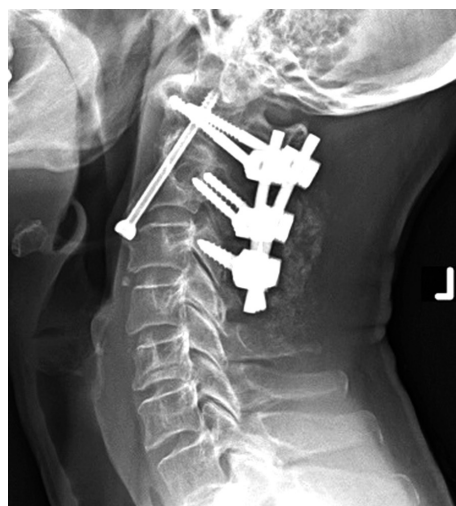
Three-month postoperative lateral radiograph of posterior fixation performed for odontoid screw nonunion. Note the dorsal fusion mass evident at 3-months postoperative.
